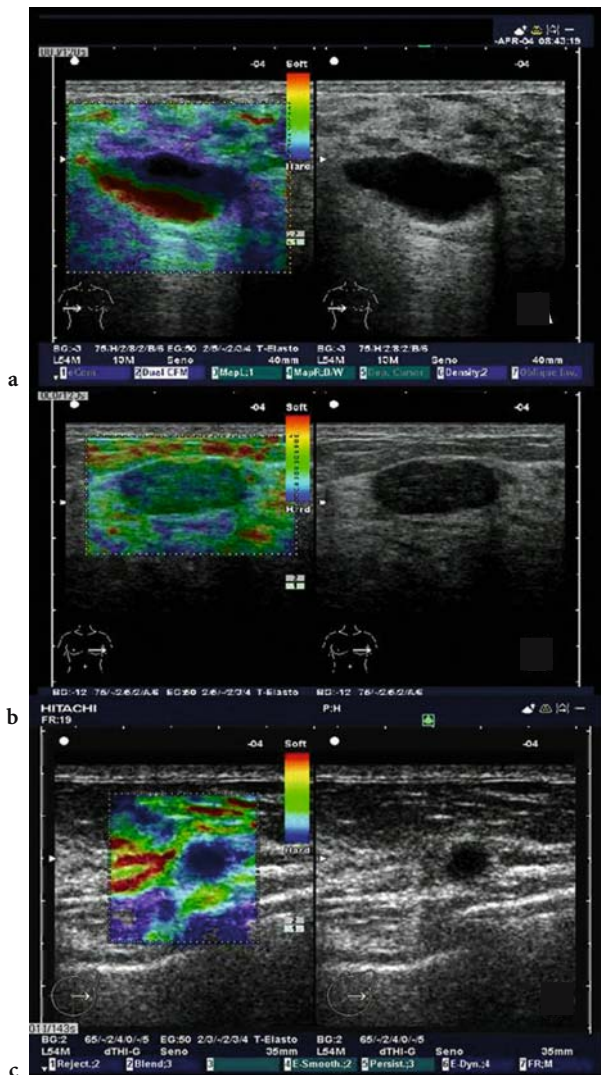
Paradigmatic findings of elastosonography: a cyst, b benign node, c carcinoma
